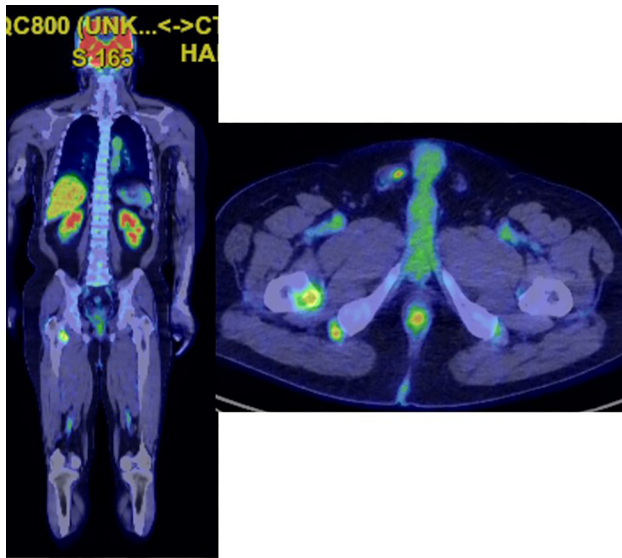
Positron emission tomography-computed tomography demonstrating abnormal uptake with a Standardized Uptake Value (SUV) of 3.3 at the lesser trochanter and 9.9 at the brain meningioma.
